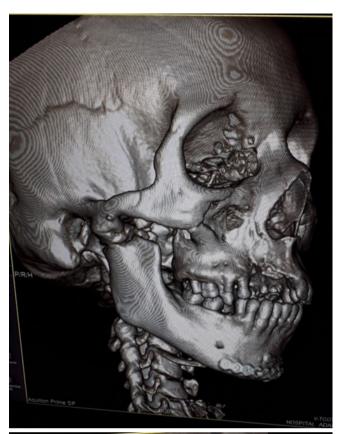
Face CT scan. 6 months postoperative period.
